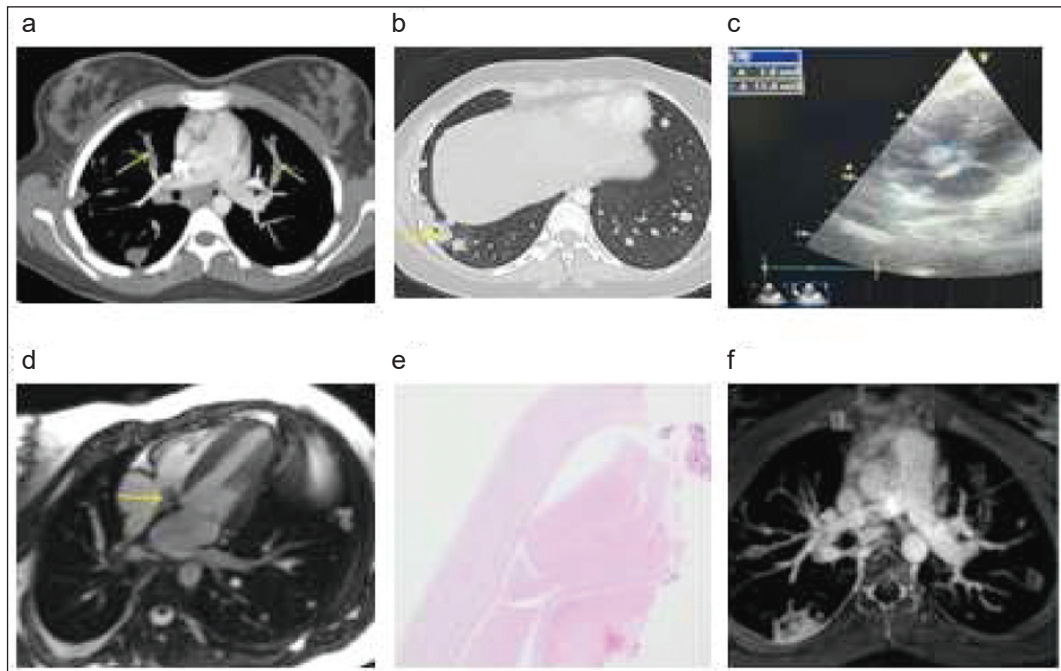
a) Pulmoner arter thrombus in thorax CT image; b) Cavitating pulmonary nodule in the lower lobe of the right lung in the thorax CT image; c) A thrombus in right atrium in the echocardiography; d) The cardiac thrombus in cardiac MRI; e) Pathology image compatible with the cyst hydatid cuticle; f) Intraarterial appearance in thoracic MRI angiography.
